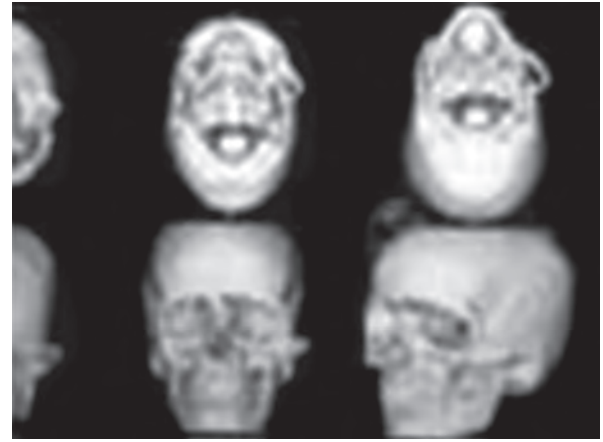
Three-dimensional CT—zygomatic fracture with dislocation
